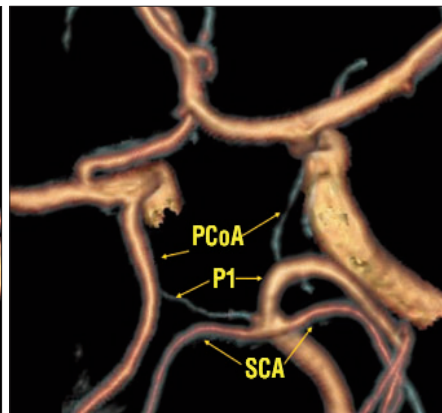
3D CT angiography reconstruction: right P1 segment hypoplasia. P1 — precommunicating segment of the PCA, PCoA — posterior communicating artery, SCA — superior cerebellar artery
